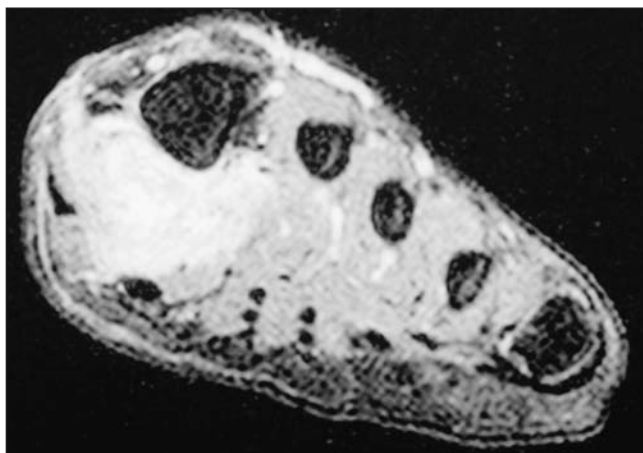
Axial T_1 -weighted magnetic resonance image of the foot.
